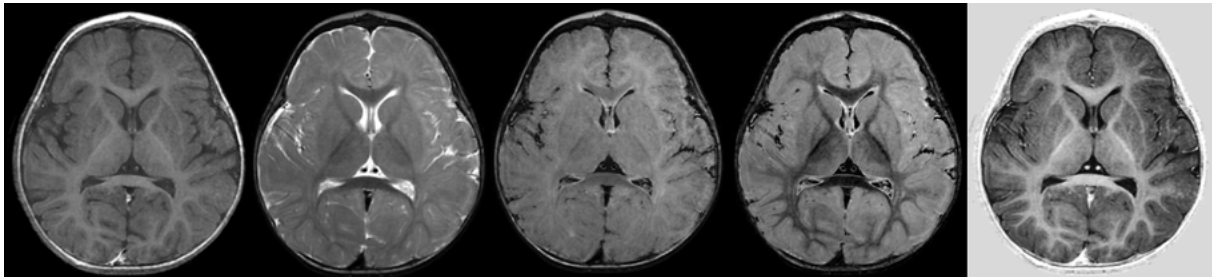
Examples of SyMRI® contrast images from a pediatric patient. From left to right T1W, T2W, T2W FLAIR, DIR, PSIR.
